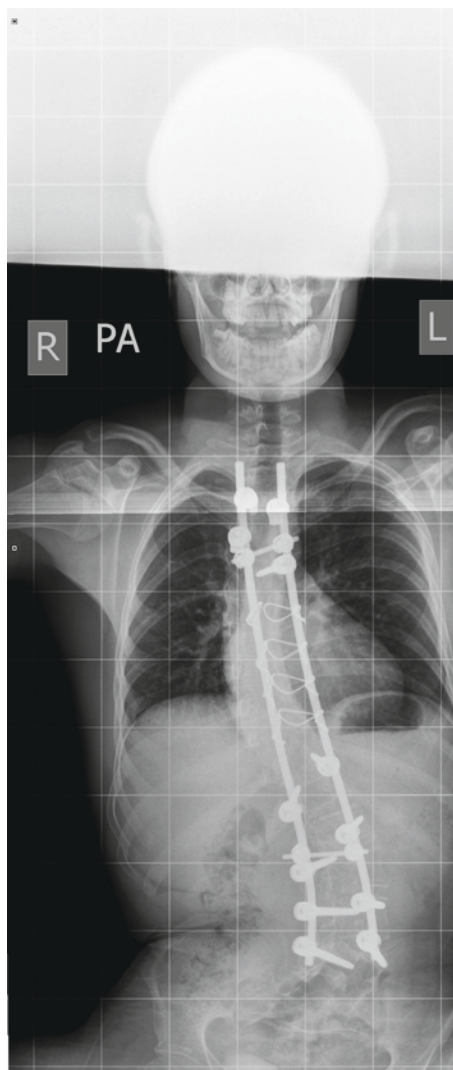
Radiograph of the spine showing scoliosis and typical instrumentation.
